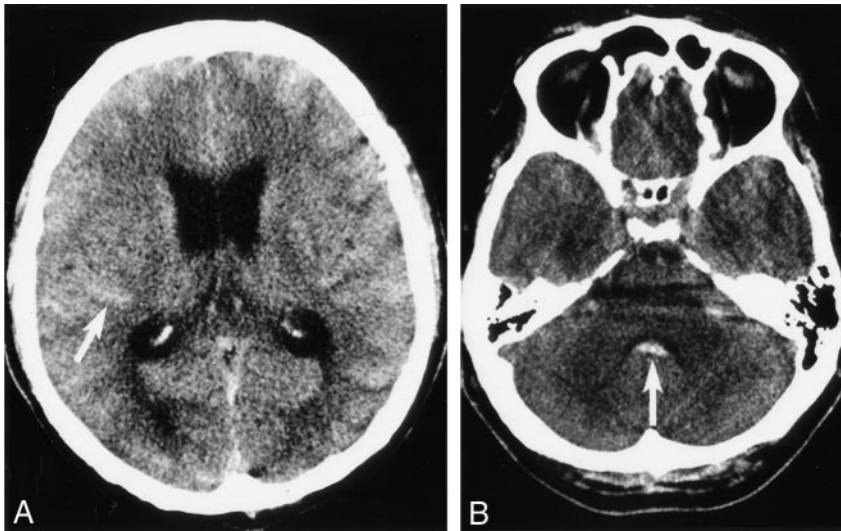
SAH. Unenhanced axial CT section of the brain (A) showing hyperattenuated cortical sulci (arrow) and (B) fourth ventricle (arrow) consistent with acute subarachnoid hemorrhage.
